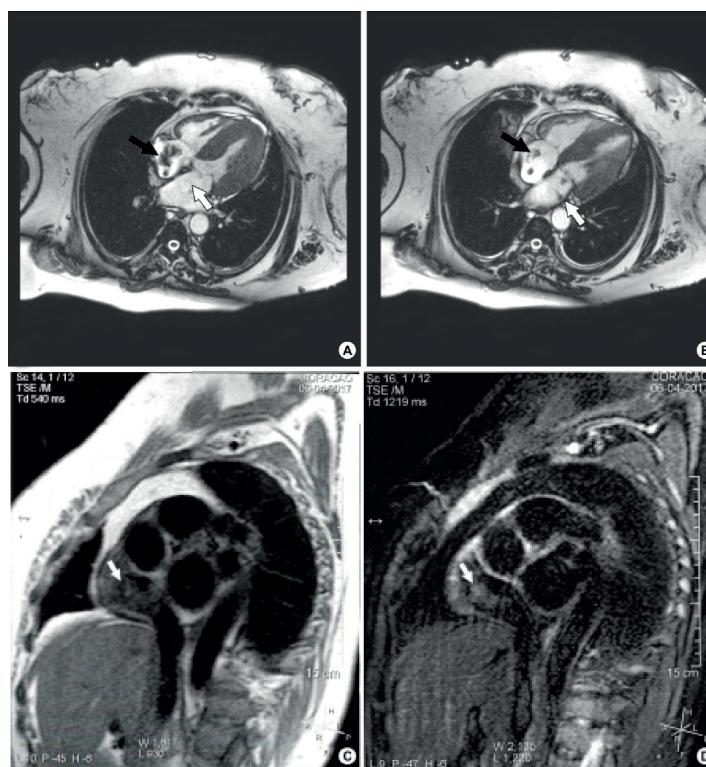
Cardiac MRI. A and B shows an irregular shaped mass, in the right atrium (black arrow), as well as two smaller masses attached to the left atrium (white arrow). C – perfusion sequence. D – late enhancement sequence.
